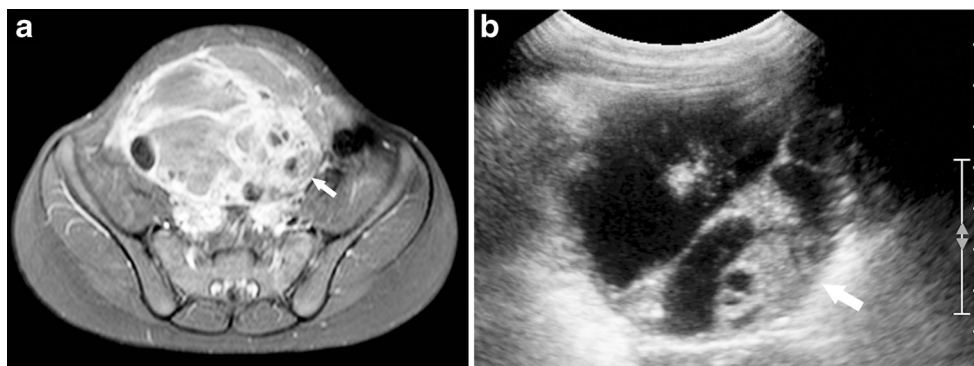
The cracked windshield imaging sign is demonstrated in a pelvic mass seen on (a) pelvic MRI (postcontrast axial fat-suppressed T1-weighted image) and (b) transverse pelvic US image in a 6-year-old girl
